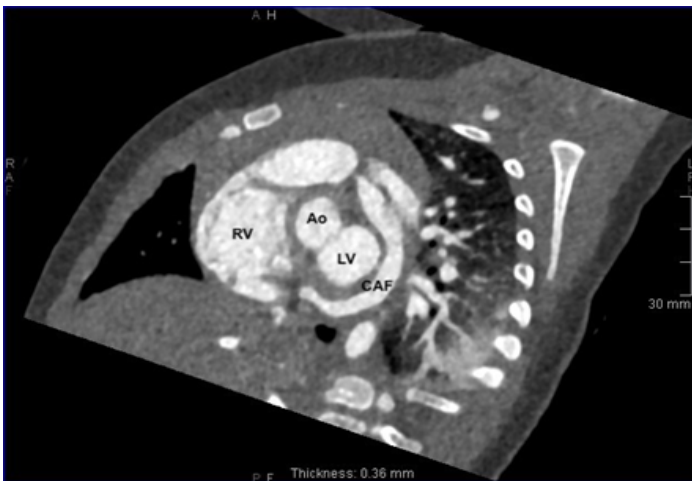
Sagittal CT (Computed Tomography) view demonstrating the course of the coronary artery fistula along the circumflex coronary artery territory and inserting into the base of the right ventricle close to the tricuspid valve. (Ao – aorta, LV – left ventricle, CAF – coronary artery fistula, RV – right ventricle).
